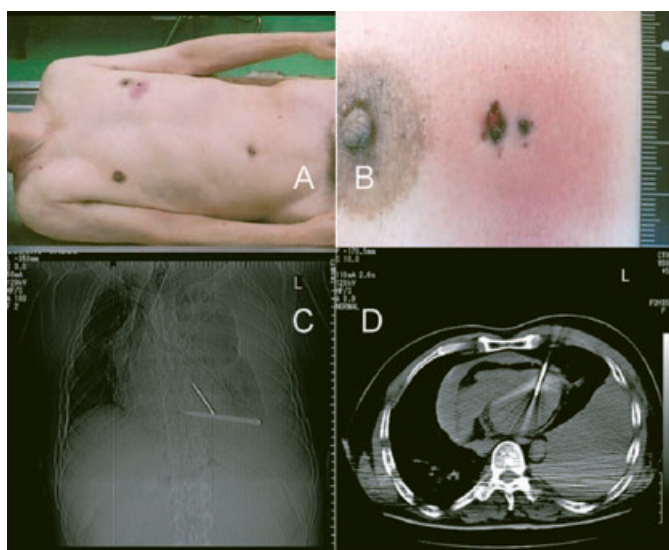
A case of a stab wound to the heart. A 60-year-old man was found lifeless at home by his wife. External examination showed only minor lesions similar to excoriation on the left anterior chest skin (A,B), which were considered likely to be a chest bruise caused by a fall when he died suddenly from heart disease. A computed tomography scan in our department found the apical part of an awl reaching the heart (C,D), which led to an autopsy. Later, the cause of death was judged as suicide when a note implying suicide was found.
